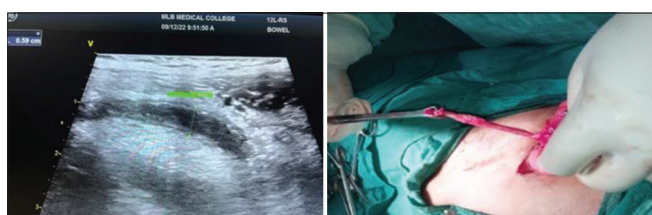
Acute appendicitis: High-resolution ultrasound image of dilated appendix with thickened wall on the right side and intra-operative image of the same patient
